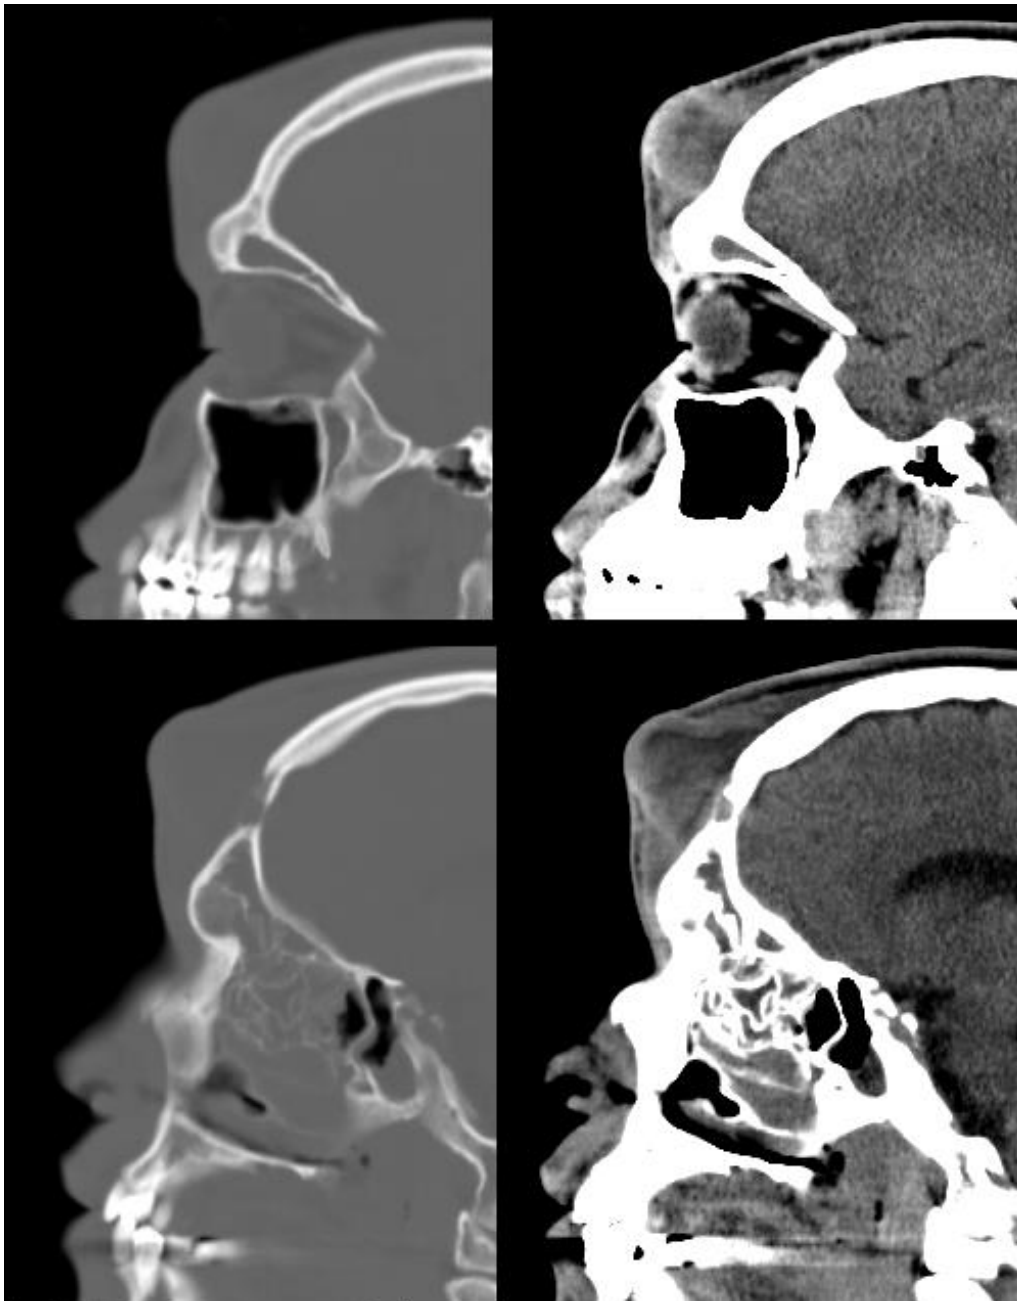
Cranial CT, Sagittal sections, bone and brain window. The appearance of an abscess forming a mass effect on the forehead and under the skin.
